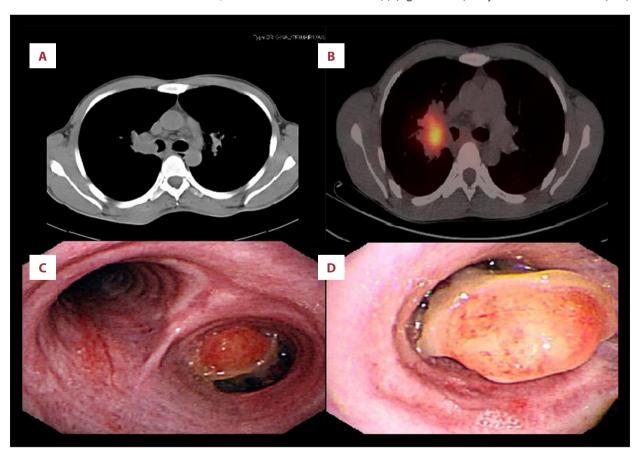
Chest CT scan displays a 3.1×2.8-cm soft-tissue-like mass at the right hilum, with enlargement of mediastinum and hilum lymph nodes, and invasion of adjacent upper lobe bronchus (A). PET/CT shows abnormal enhancement of 18F-FDG in the right hilum mass with a maximum SUV of 21.68 (B). Fiberoptic bronchoscopy shows a tube-like neoplasm at the orifice of right upper lobe bronchus and blocked the lumen of the right main bronchus (C, D).
